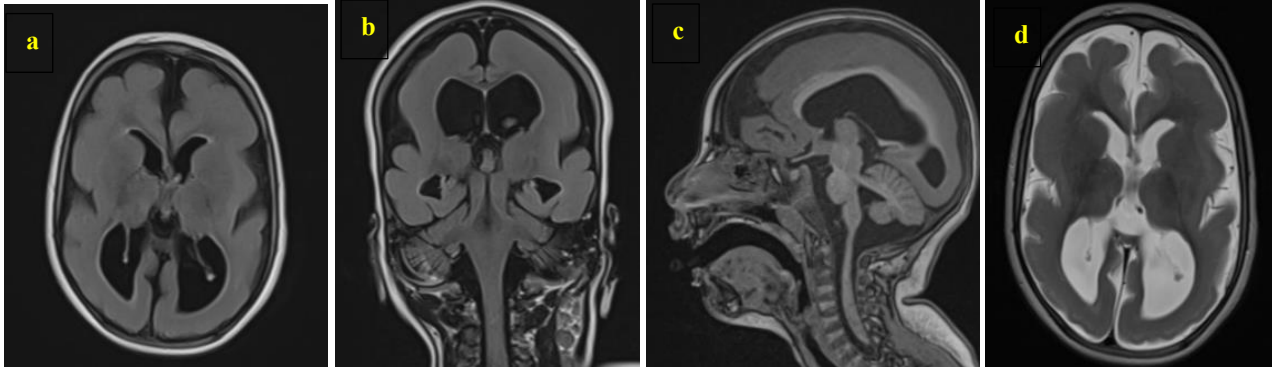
Brain MRI of the first case (FLAIR axial (a) and coronal (b); 3D T1 sagittal (c) and T2 axial (d)) demonstrated a diffusely smooth cortical surface at the supratentorial level (a, b, c), with a characteristic anteroposterior gradient (c). Enlargement of the supratentorial and infratentorial subarachnoid spaces with moderate ventriculomegaly, without signs of transependymal cerebrospinal fluid resorption (d). An enlarged posterior cranial fossa communicating with the fourth ventricle was also observed (c)
